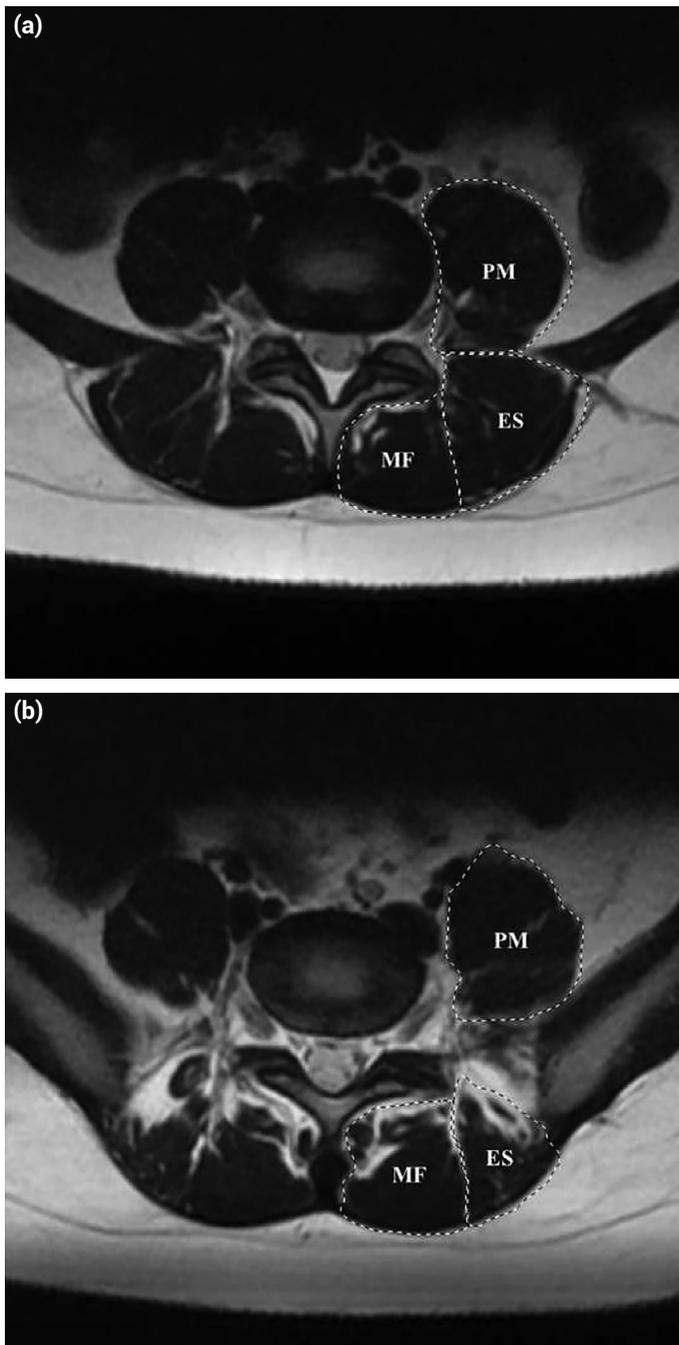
Lumbar spinal magnetic resonance imaging of a patient. Contours of the psoas major, multifidus, and erector spinae muscles in axial T2-weighted images at (a) L4–5 and (b) L5–S1 intervertebral disc levels
